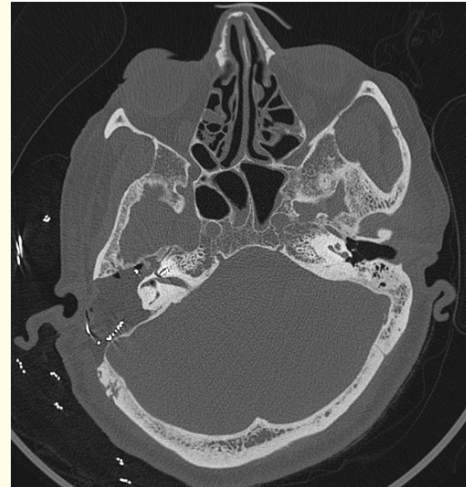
HRCT - axial view showing the extent of surgery, CI electrode noted in position.
